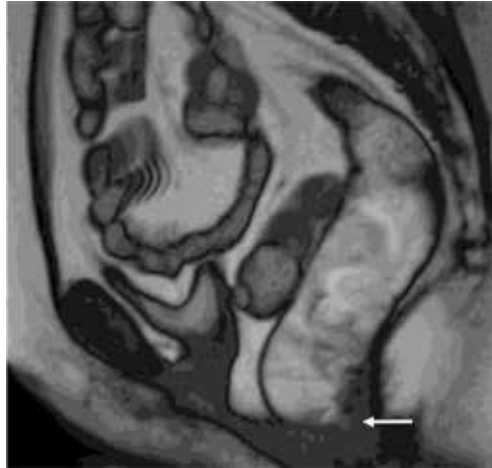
Mid-sagittal gradient echo MR image of the pelvis during evacuation in a patient with chronic constipation show persistent puborectalis muscular contraction (arrow) without expulsion of intra-rectal gel.*
